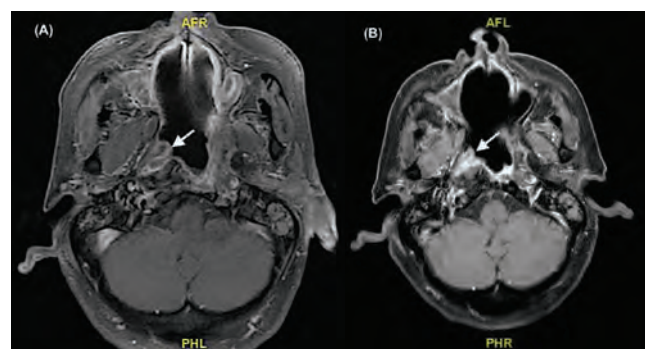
Axial views of T1-weighted magnetic resonance imaging with contrast taken in 2012 after left nasopharyngectomy (A) and after 8 years of topical 5-FU application (B). White arrow marks the tumour, which has not changed in size due to the topical regime.
